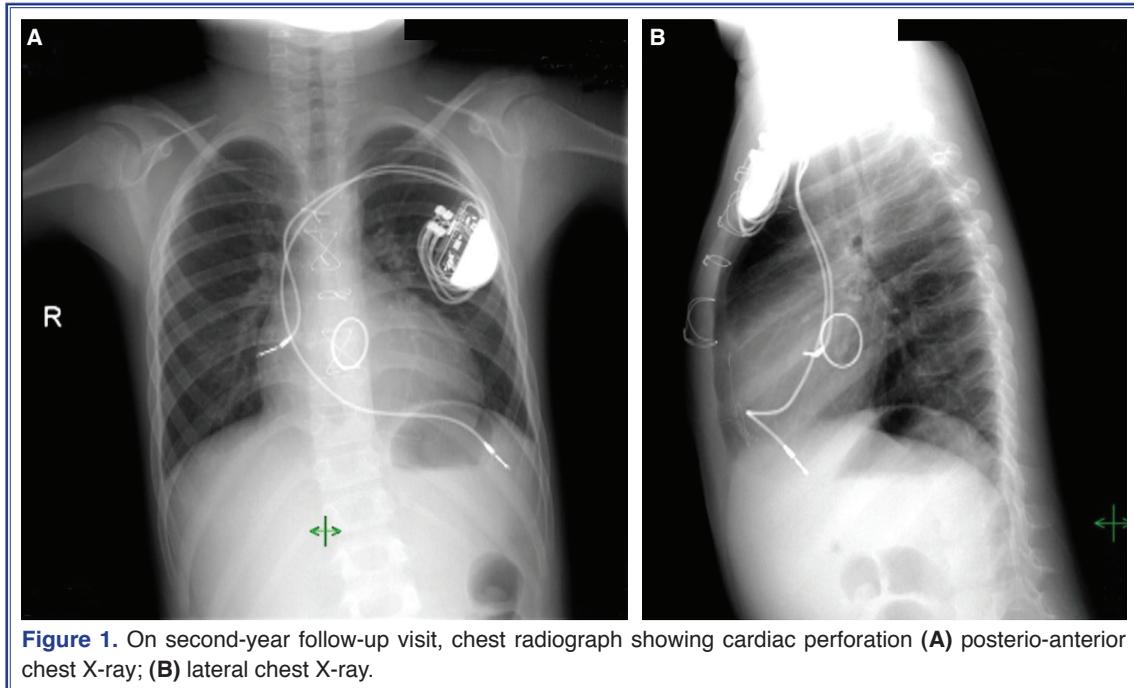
On second-year follow-up visit, chest radiograph showing cardiac perforation (A) postero-anterior chest X-ray; (B) lateral chest X-ray.
